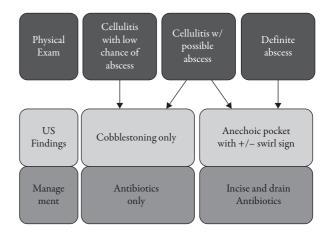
Guide on the use of ultrasound in abscess evaluation.
